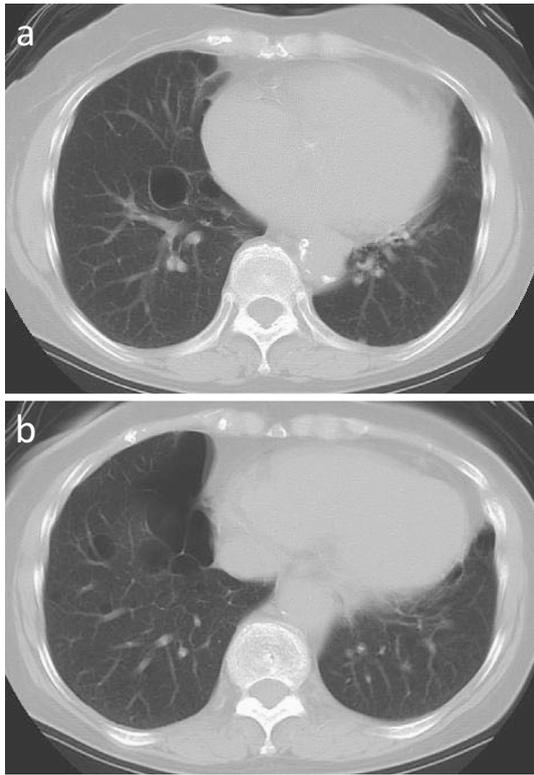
CT of the chest (5-mm section thickness) revealed irregularly shaped lung cysts of varied sizes located predominantly in the bilateral lower medial zone. Images at the level of the right atrium (a) and inferior vena cava (b).
